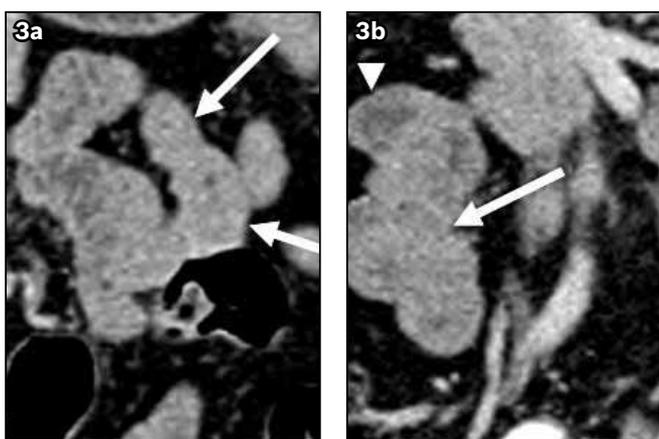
Abdominal CT images of a 46-year-old woman who received 0.1% gastrografin as an oral contrast agent. (a) Poor mural and mucosal fold visualisations (white arrows) are seen for the jejunum. (b) Grade 2 bowel distension (white arrowhead) and poor discrimination of the bowel loops (white arrow) are seen for the ileum.
